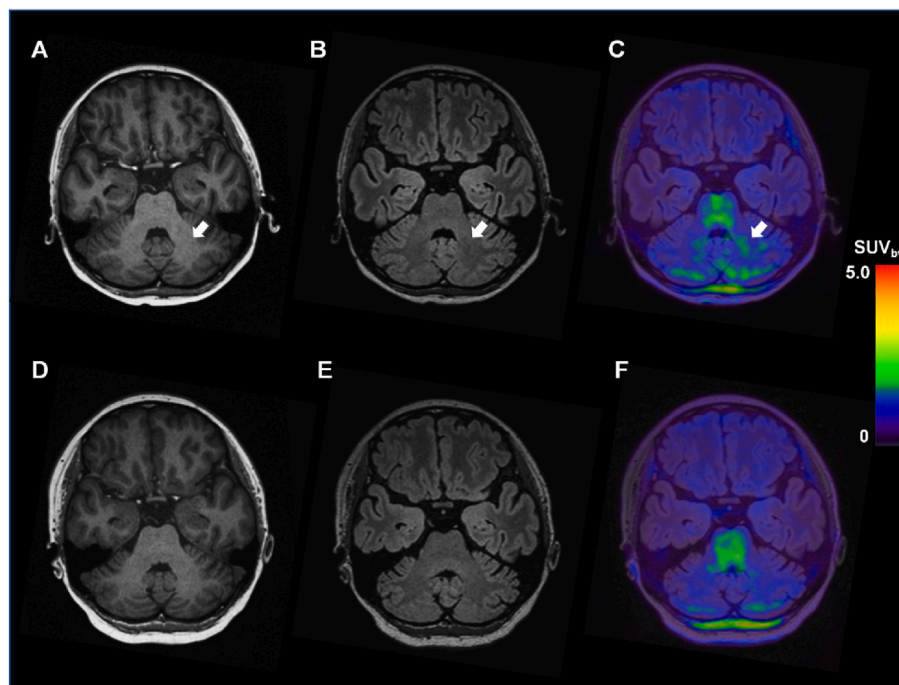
A significant increase of ^{18}F -DPA714 uptake (white arrow) in the cerebellum was found without any structural or signal abnormalities on A) T1W, B) T2 FLAIR images and C) hybrid ^{18}F -DPA-714 PET/T2 FLAIR images. Post-treatment PET/MRI showed reduced ^{18}F -DPA714 uptake in the bilateral cerebellum on D) T1W, E) T2 FLAIR images and F) hybrid ^{18}F -DPA-714 PET/T2 FLAIR images.
